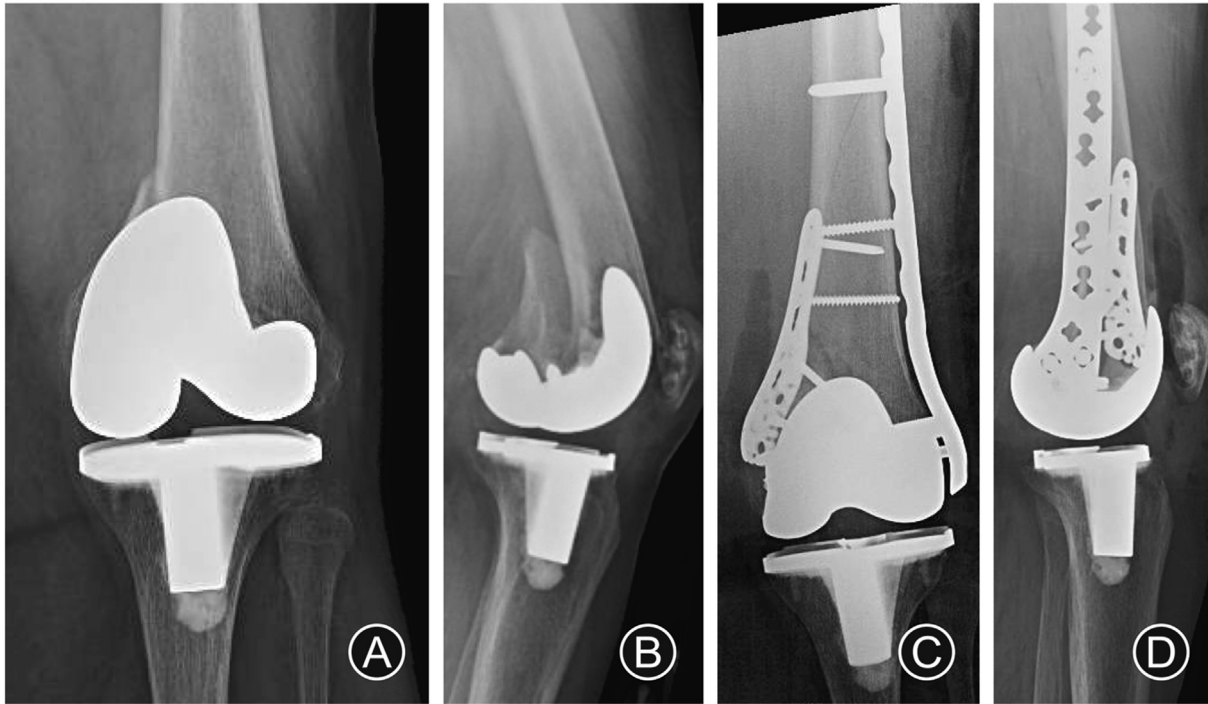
Case 3: treatment of a Rorabeck type 2 distal femur fracture treated with a medial proximal humeral locking plate associated with a long distal femur locking plate. (A) and (B): Radiographs in anteroposterior and lateral views showing a distal femur periprosthetic fracture. (C) and (D): Radiographs in anteroposterior and lateral views depicting fracture fixation with a medial proximal humeral locking plate (Philos plate, DePuy Synthes®) associated with a long distal femur locking plate.
